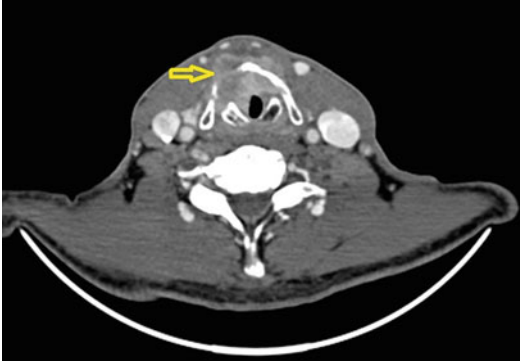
Contrast-enhanced CT neck showing a supra-glottic tumor with cartilage erosion and exolaryngeal spread (yellow arrow)
